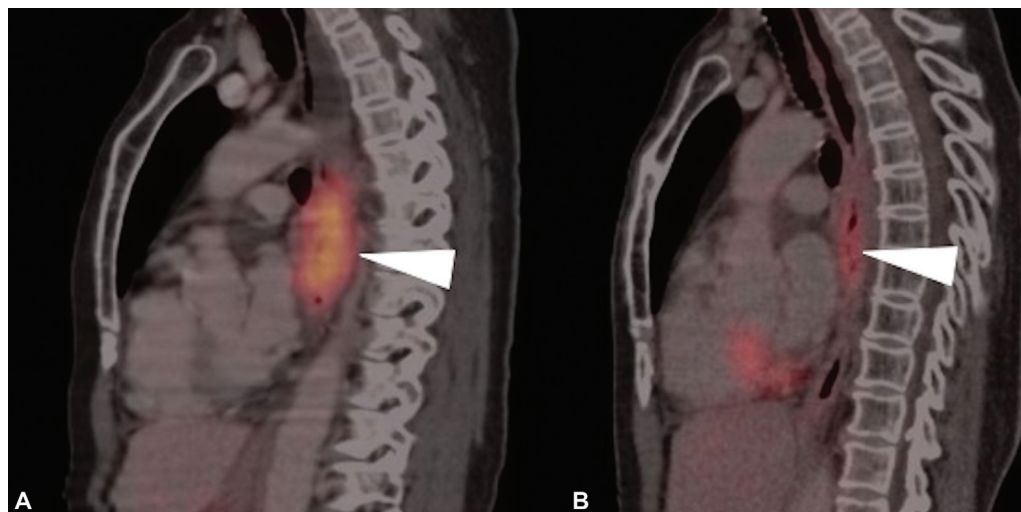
(A and B) Fluorodeoxyglucose-positron emission tomography/computed tomography (FDG-PET/CT) images of a 50-year-old patient diagnosed as metastatic carcinoma esophagus treated with radiotherapy (RT). (A) Sagittal pretreatment PET/CT image depicts the metabolically active primary neoplastic mass lesion (arrowhead). (B) Sagittal post therapy PET/CT image after 3 months of RT reveals significant reduction in metabolic activity of primary lesion, suggestive of significant metabolic remission.
